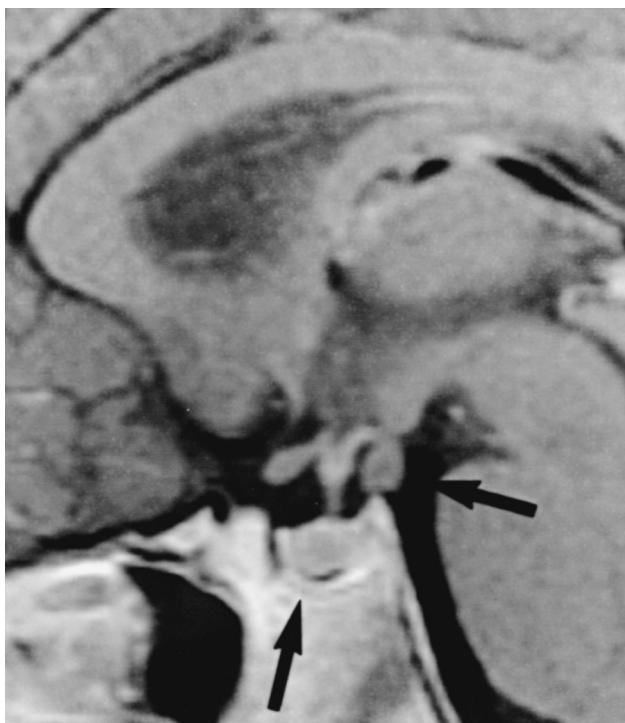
Magnetic resonance image showing a hypothalamic hamartoma (right-hand arrow) as the cause of true sexual precocity in a 2.5-year-old girl. The hamartoma is hanging from the floor of the hypothalamus just posterior to the pituitary infundibulum. The sella turcica (bottom arrow) contains a normal pituitary gland with pituitary stalk hanging from the infundibulum.
